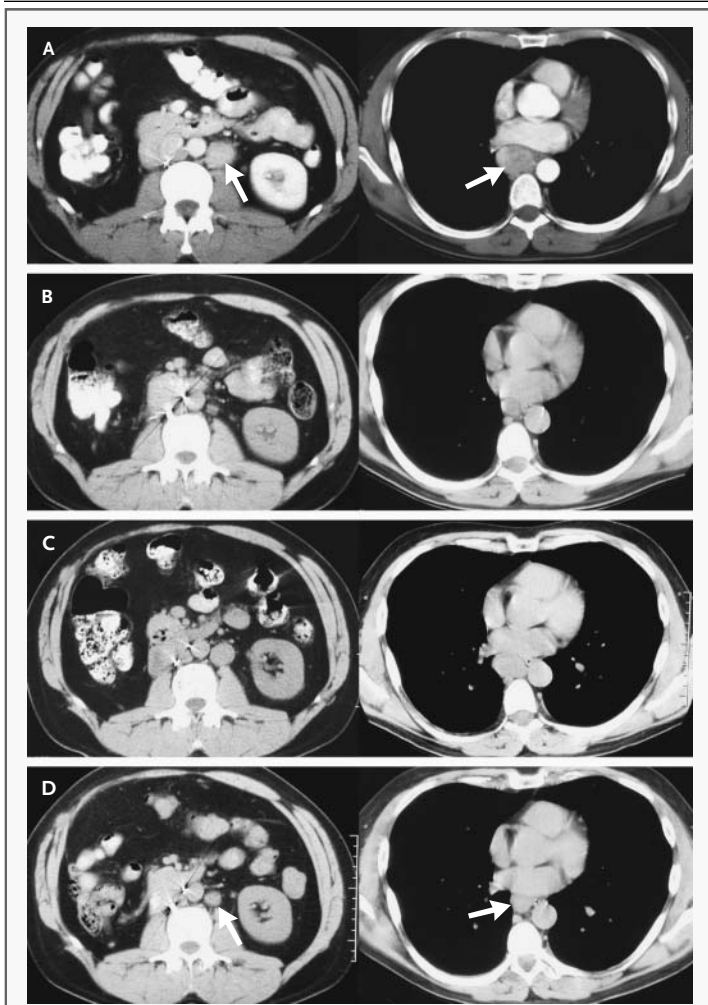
Serial Radiographs of a Patient Treated with High-Dose Bevacizumab.
